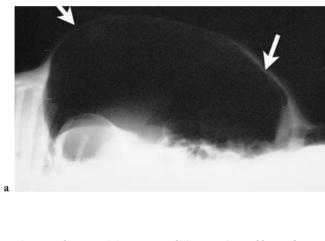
Necrotizing enterocolitis. a Horizontal beam decubitus radiograph that shows pneumoperitoneum (*arrows*) due to bowel perforation in a premature infant. b Same patient. Contrast enema performed 6 months after surgery demonstrates a solitary, short stricture at the transverse colon
